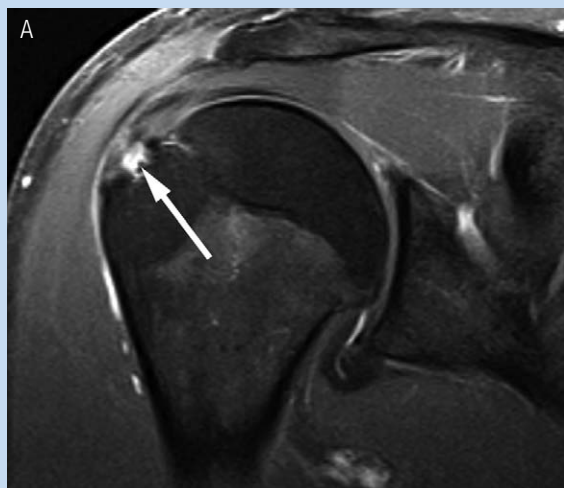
Fat-suppressed T1-weighted coronal images obtained following intravenous contrast administration in a professional baseball pitcher. Focal enhancement within a small partial articular surface supraspinatus tear (arrow) and within the adjacent greater tuberosity (arrowhead) is seen.
